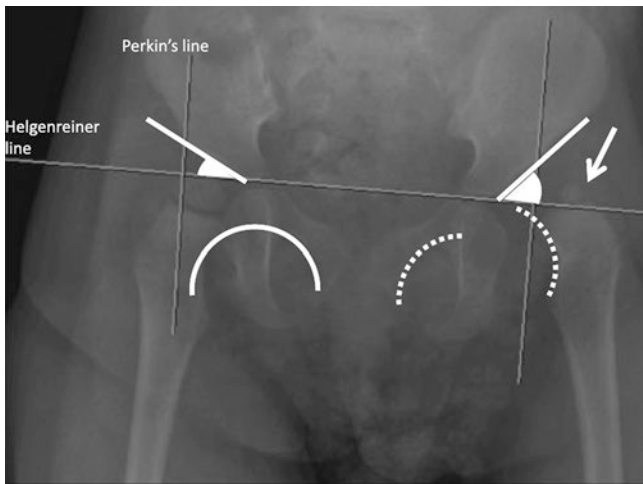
Anteroposterior pelvis radiographs of a 14-month-old girl with developmental dysplasia of the left hip. The radiograph shows the ossific center on the left side (arrow) smaller than the right side and lying in the *upper lateral quadrant* of the crossing two lines (Hilgenreiner and Perkins; the normal right side lies in the *lower medial quadrant*). The Shenton line (curved line across the obturator foramen and lower border of the neck) is intact on the right side (continuous curved line) and broken on the left side (curved dotted line). The dislocated side shows increased acetabular index (the angle between the Hilgenreiner line and line from the triradiate to the lateral part of the acetabulum)
